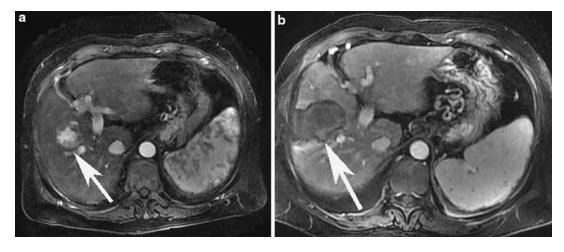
MWA in a 60-year-old woman with HCC adjacent to the hepatic hilum. (a) Contrast-enhanced MRI before MWA shows a 3.6×3.5 cm arterially
